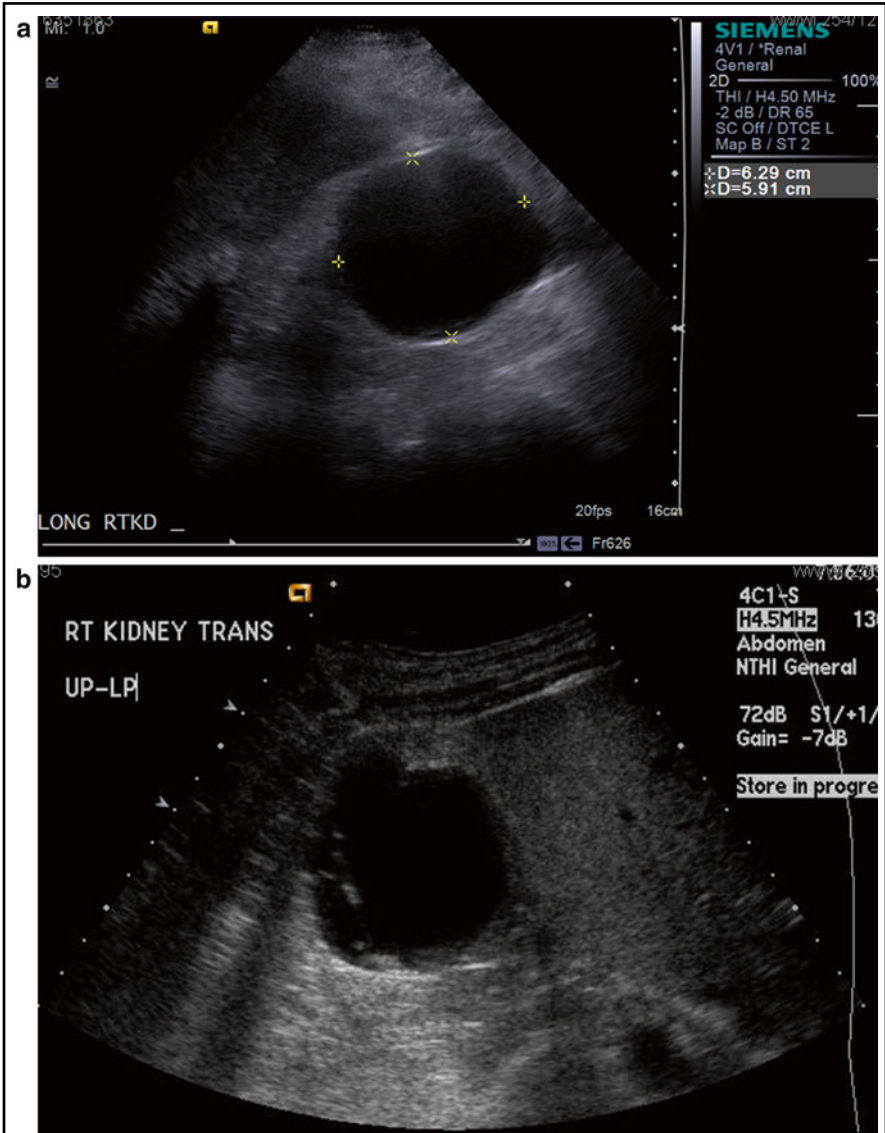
(A) ULTRASOUND IMAGE OF A SIMPLE RENAL CYST
